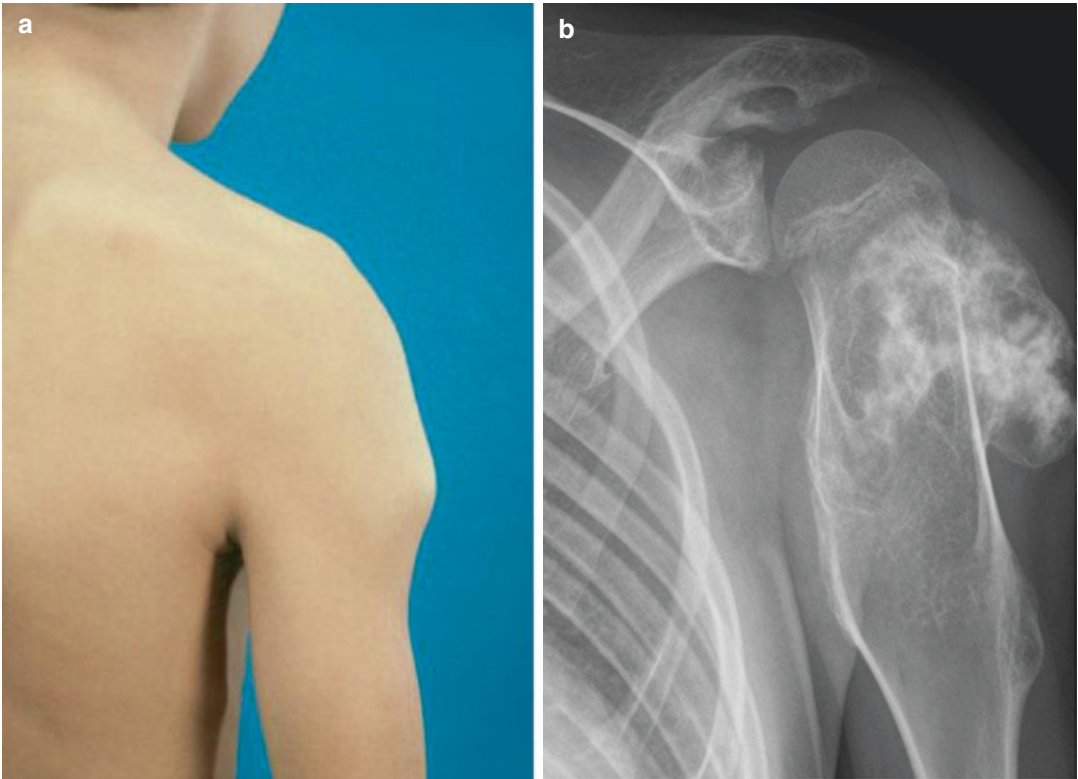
(a) Osteochondroma (exostosis) at the level of the proximal part of the humerus. (b) X-ray of this osteochondroma
